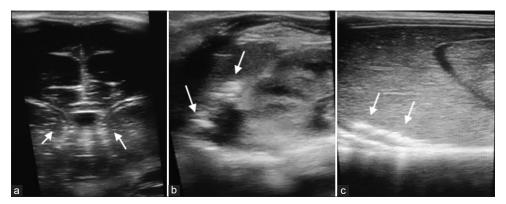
Ultrasound images demonstrating calcification (white arrows). (a) Periventricular calcification with multiple calcifications along the vessels within the thalami, (b) renal calcifications, and (c) hepatic calcifications on postnatal day 2.
